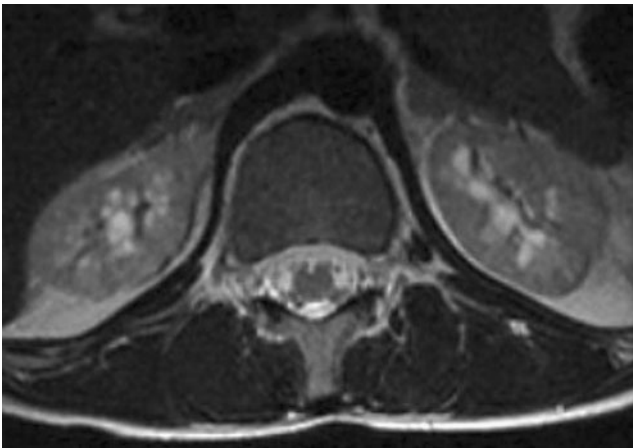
Axial T2-W MRI of the kidneys
